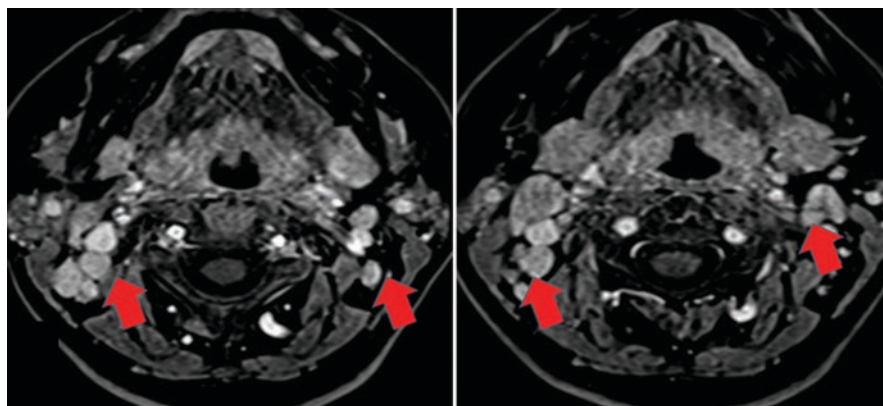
Axial MRI images displaying retropharyngeal nodes
